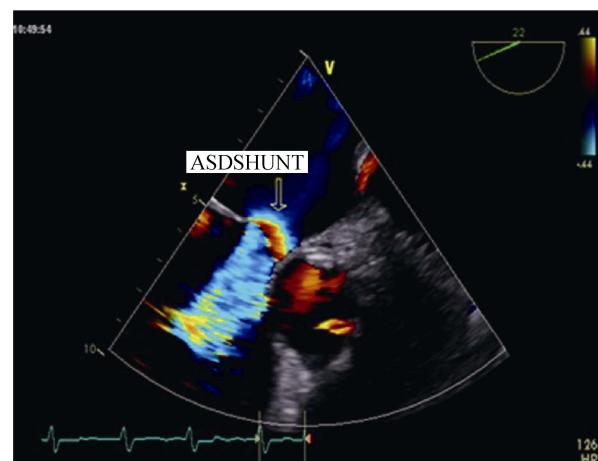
Color Doppler image of the left-to-right shunting (yellow arrow) across the atrial septal defect with a size of approximately 12 mm.
